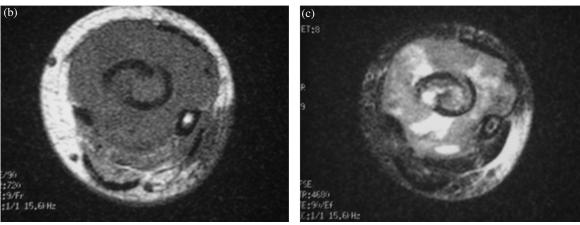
MR in staging of osteosarcoma of the tibia. (a) Coronal T1-weighted MR image shows a pathological fracture through the distal tibial lesion. The superior-inferior medullary lesion extent and soft tissue component are well depicted. Axial (b) T1- and (c) T2-weighted MR images show not only lesion abutment upon the distal fibula but also extensive involvement of the adjacent muscles and neurovascular structures.
